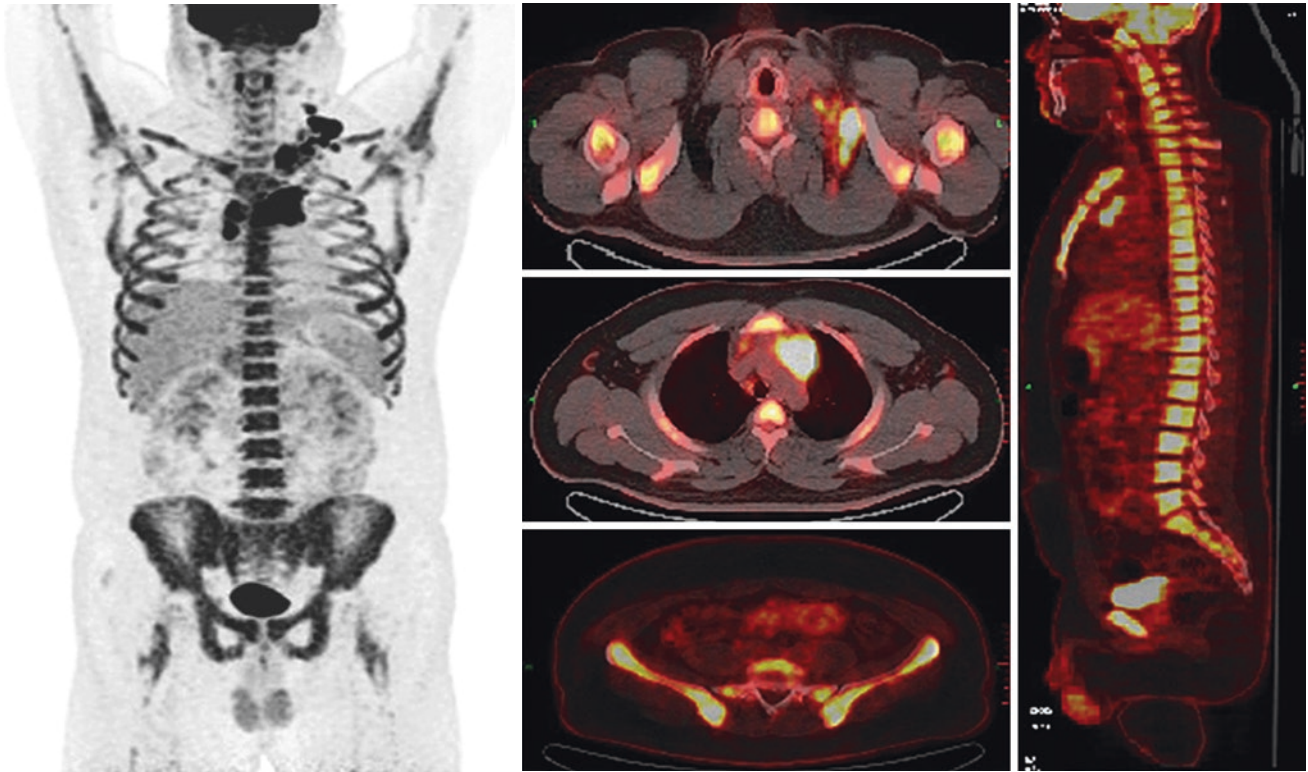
Demonstrate multiple lymph node enlargement and abnormal increase of FDG uptake ($SUV_{max} = 14.9$). Systemic skull with high FDG metabolism ($SUV_{max} = 9.5$)
